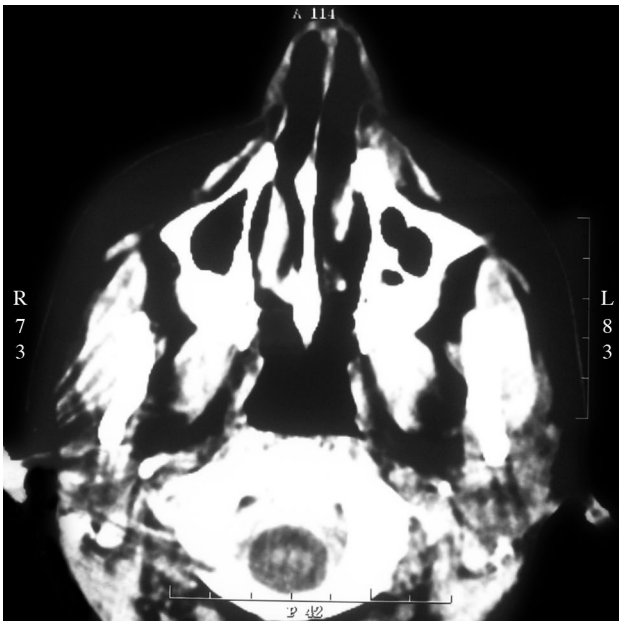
Paranasal computed tomography of the patient in axial plane demonstrating hypodense soft tissue swelling on the left.
